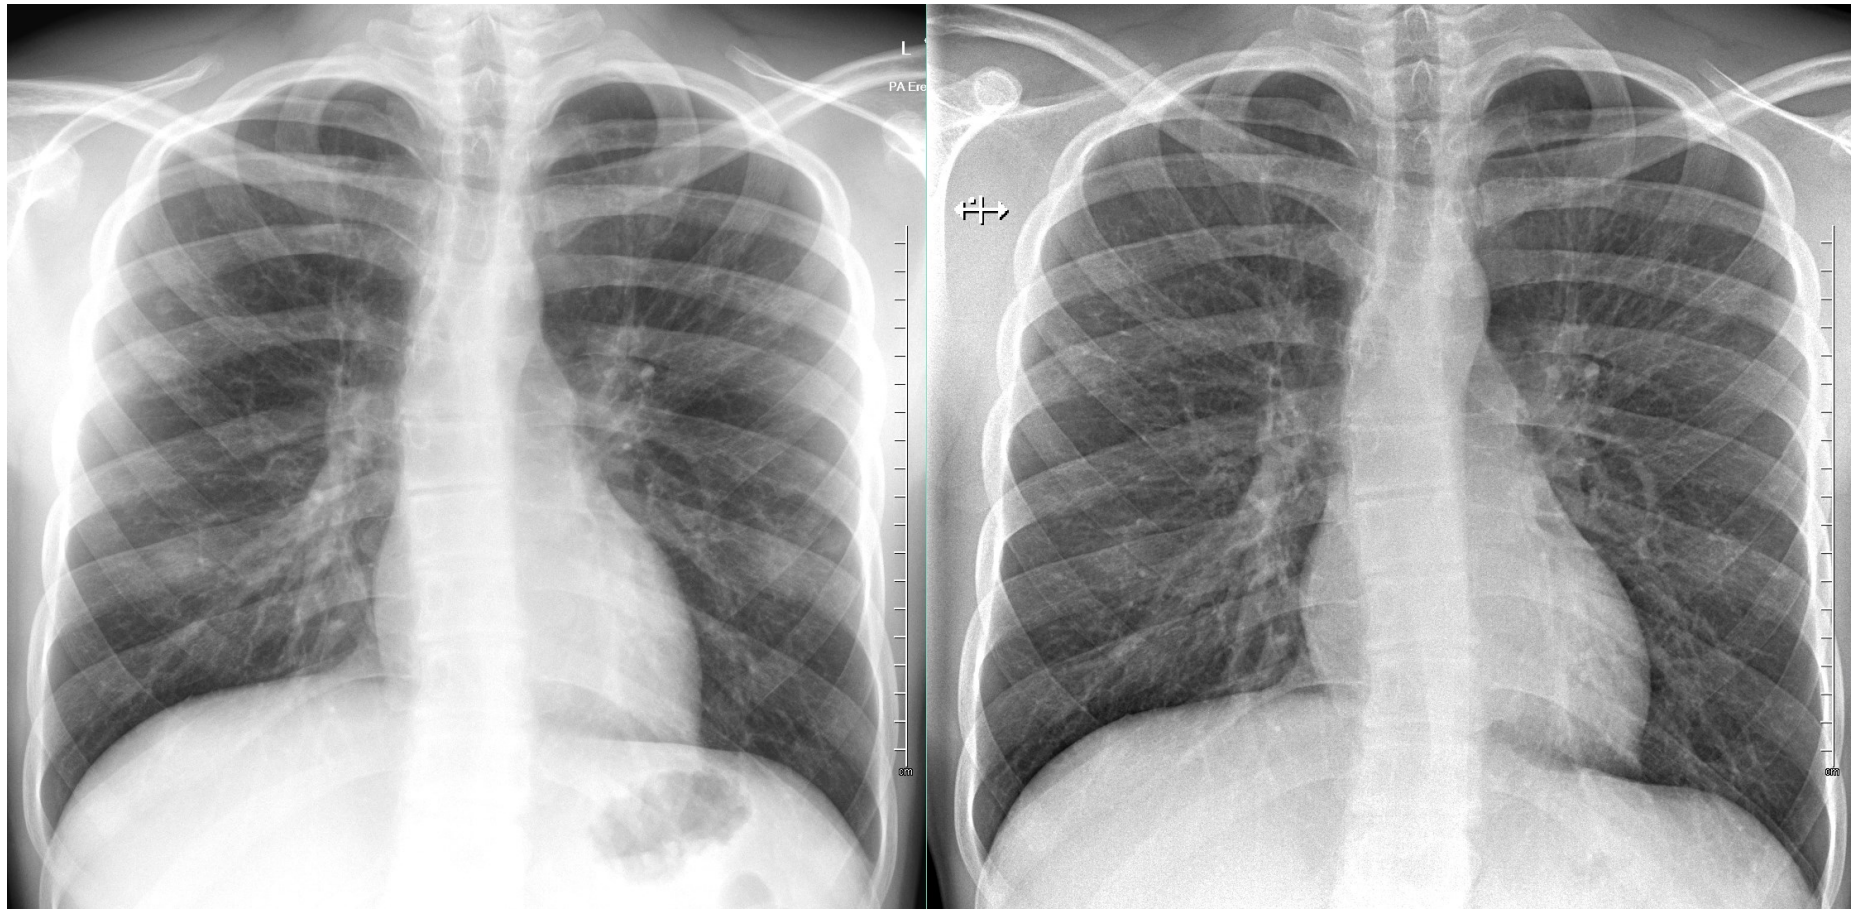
Chest X-rays of M17 taken 6 months before BT (Before) and 6 months after completion of bacteriophage therapy (After).
